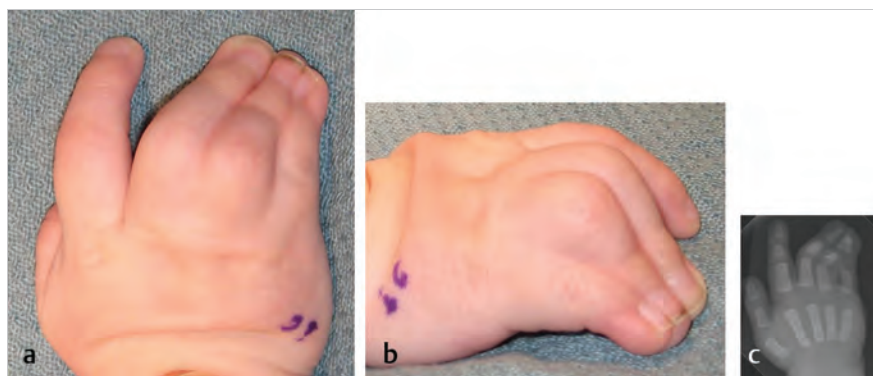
Demonstration of angular deformity due to complete complex syndactyly involving the fourth webspace. (a) Dorsal view. (b) Oblique view. (c) Radiographic view.
